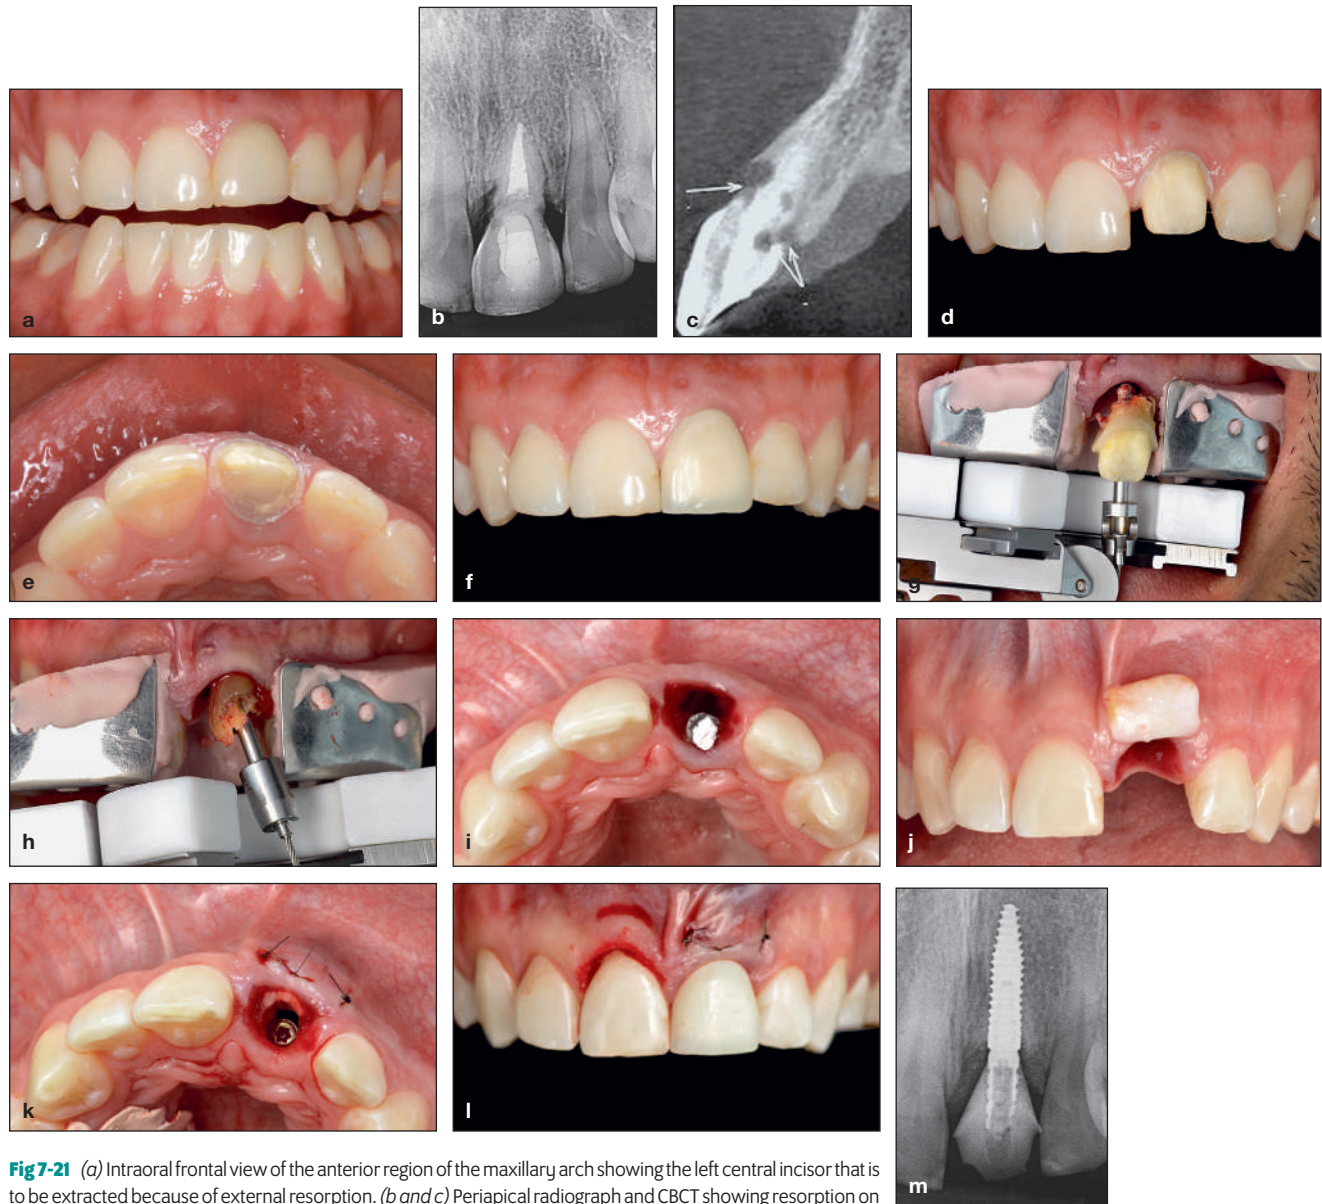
(a) Intraoral frontal view of the anterior region of the maxillary arch showing the left central incisor that is to be extracted because of external resorption. (b and c) Periapical radiograph and CBCT showing resorption on the cervical aspect of the root (mesial and distal). (d and e) Frontal and occlusal views showing crown preparation for a full-coverage provisional restoration. The provisional restoration will be modified and used after tooth extraction as an implant-supported provisional restoration. (f) Left central incisor with the provisional restoration in position. (g and h) Atraumatic extraction of the tooth. Because of the resorption process, the coronal and radicular parts of the tooth were removed separately. (i) Occlusal view of the extraction site after implant placement. Note that the implant has been positioned more palatally. The gap between the buccal plate and the implant surface will be filled with bone substitute material for volume preservation and a soft tissue graft. (j) Soft tissue grafting was performed to optimize the position of the gingival contour and papilla level. (k) Bone substitute material was then used to maintain bone volume. (l) Frontal view of the provisional crown in place after the completion of surgical procedures. Note that the soft tissue contour of the right central incisor was modified to increase the length of the crown. (m) Periapical radiograph of the installed implant. (Surgical photographs courtesy of Dr Jose Alfredo Mendonça.)
